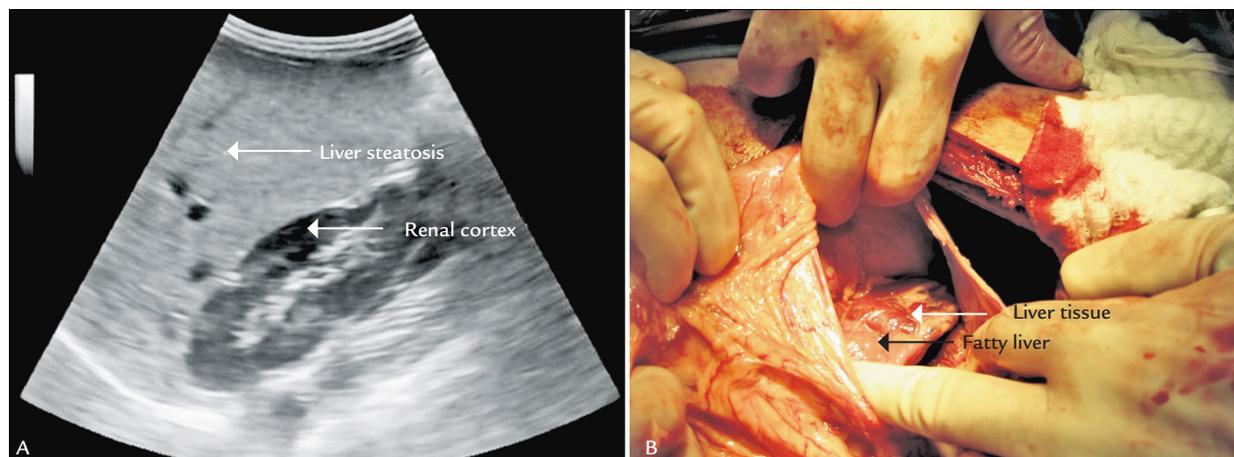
A. Ultrasonography of liver steatosis. B. Hepatosplenic schistosomiasis and liver steatosis.
